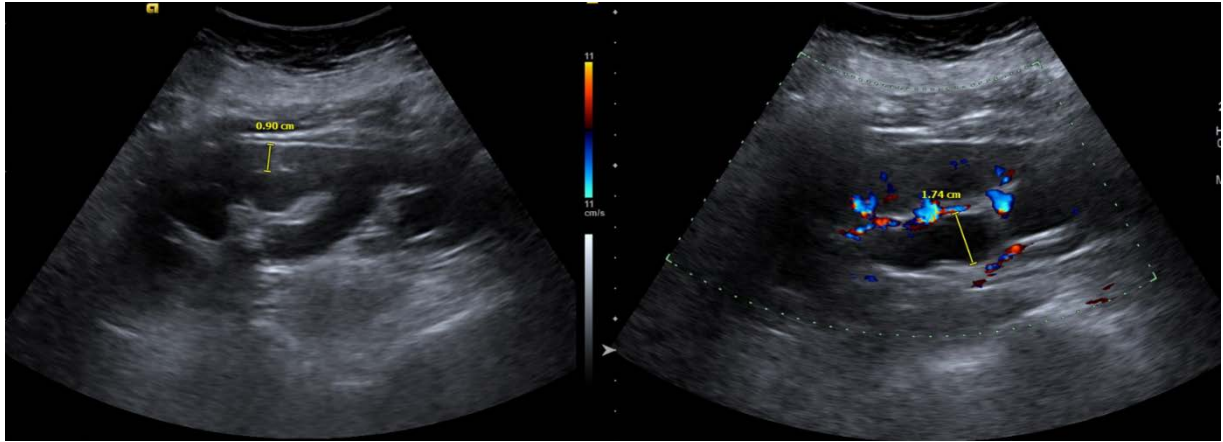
On the renal ultrasound, the right kidney measures 4.7 x 12.9 x 4.9 cm. The renal cortex measures in 9mm thickness. The calyceal depth measures 17mm. The right ureter is not well visualized on the ultrasound.
